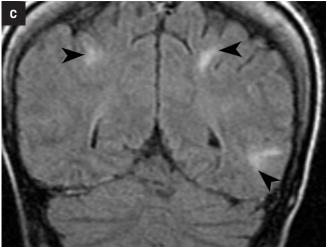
A child with abdominal pain and neurological symptoms. Axial contrast-enhanced abdominal CT image (A) shows diffuse smallbowel wall thickening (black arrow), resulting in Target appearance. Magnetic resonance angiography of the cerebral vessels (B) shows multifocal stenoses in both MCAs (white arrowheads). The patient was later diagnosed with systemic lupus vasculitis. Coronal FLAIR MRI of the brain (C) shows multifocal subcortical white matter lesions (black arrowheads).
